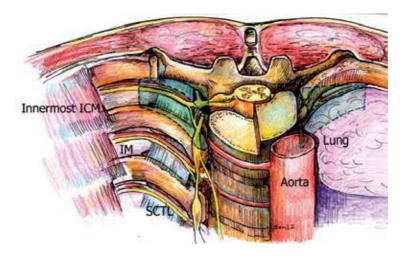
The median distance from skin to paravertebral space is 5.5 cm, with greater depth in the upper (T1-3) and lower (T9-12) thoracic regions (WR). Body habitus significantly influences the depth to this space, which can be measured using ultrasound.
